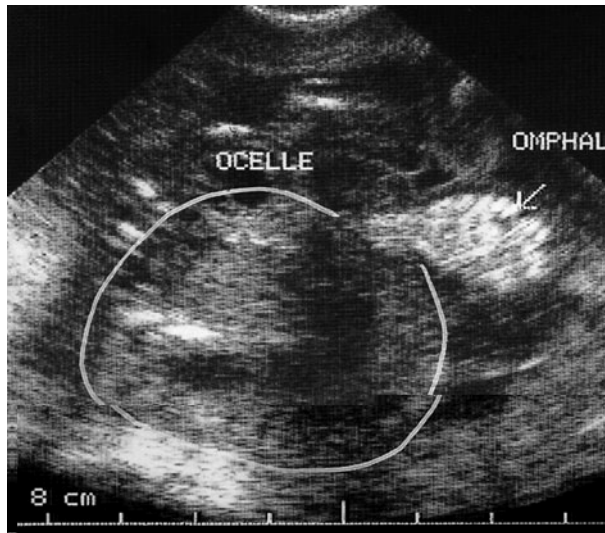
Transvaginal ultrasonogram showing a 15-week-old fetus with omphalocele (arrow). Bowel loops protrude through the abdominal wall defect.
